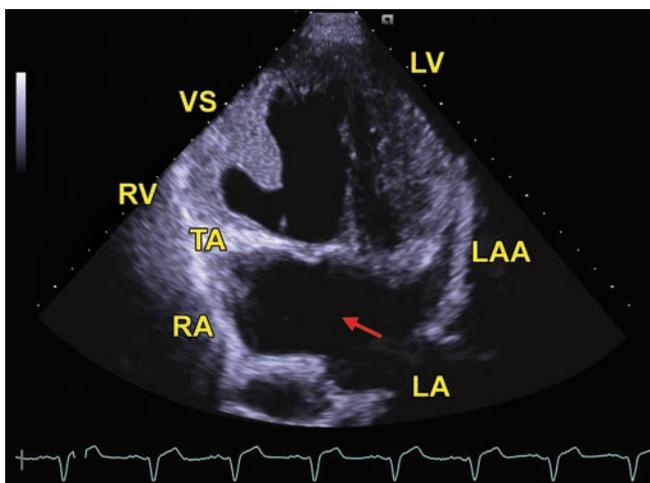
Apical four-chamber view showing absence of right atrioventricular connection with atrial and ventricular septal defects. In the left atrium (LA), the left atrial appendage is seen. Arrow points to ASD.
